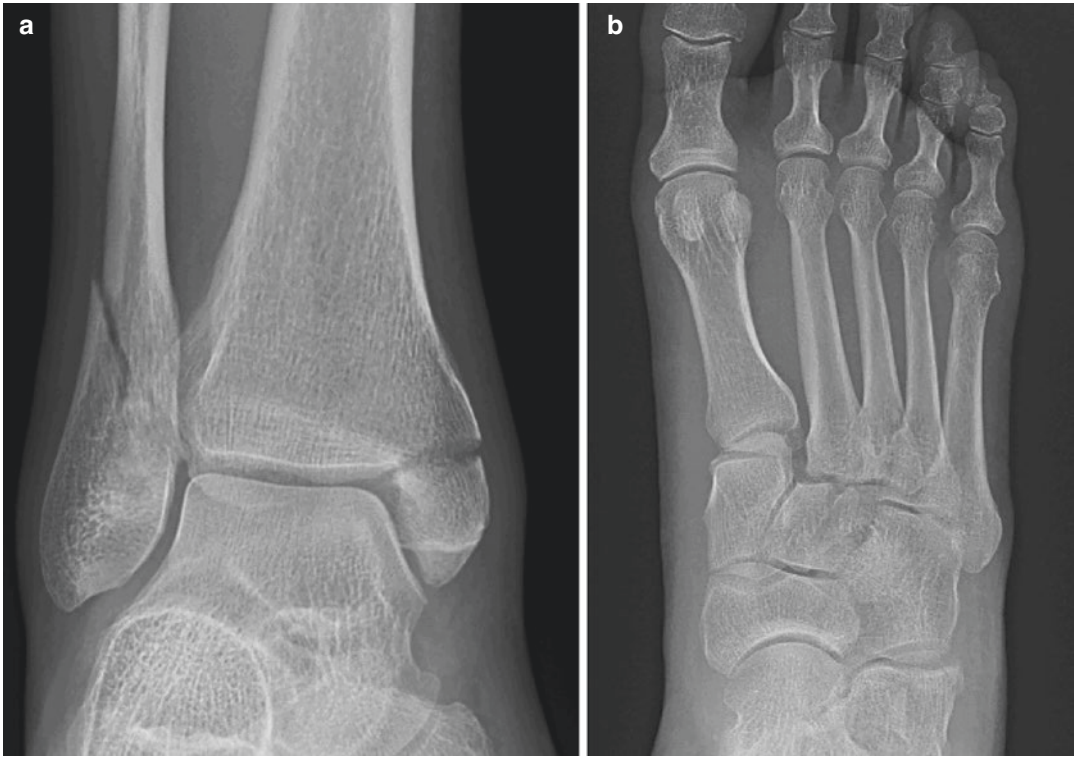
(a, b) Patient is a 70-year-old male who had a forklift injury to the right ankle. He sustained a combined ankle and midfoot injury. (a) AP radiograph of the right
